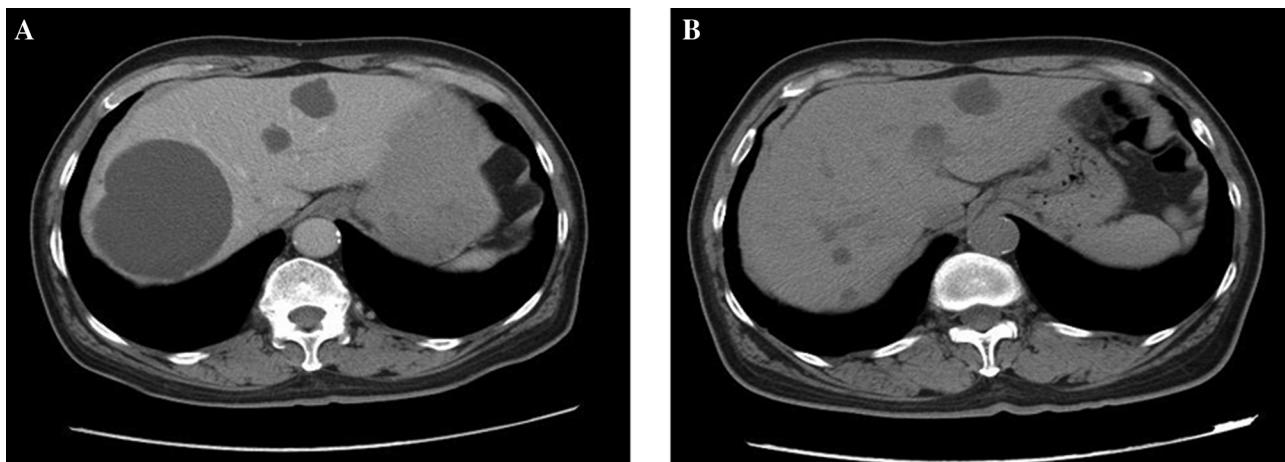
Representative CT images of a 50-year-old male patient with SHC treated by repeated rapid alcohol-instillation sclerotherapy. Transverse CT images were obtained (A) before treatment and (B) six months after repeated rapid alcohol-instillation sclerotherapy. The larger right-lobe cyst basically disappeared after treatment. In contrast, the untreated smaller cysts in the left lobe of the liver showed no obvious changes in size.
